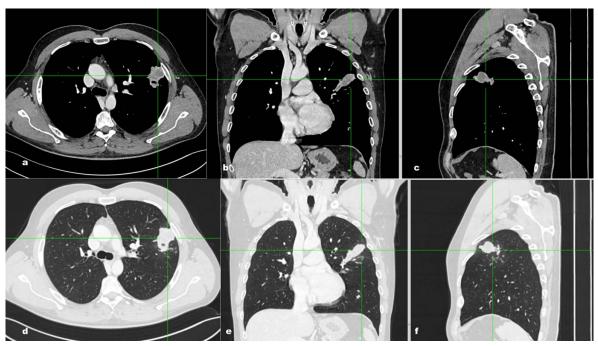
(4a-f) Axial (4a,4d), coronal(4b,4e) and sagittal (4c,4f) thin-section contrast-enhanced CT scan in portal venous phase (4a-4c: mediastinal windowing and lung windowing) shows a parenchymal consolidation measuring 38x44x48 mm in the superior lingular segment of the left upper lobe. This lesion is characterized by irregular margins with strands extending to the hilar region and adjacent pleural plane, it also demonstrates inhomogeneous density due to the presence of colliquative areas.
